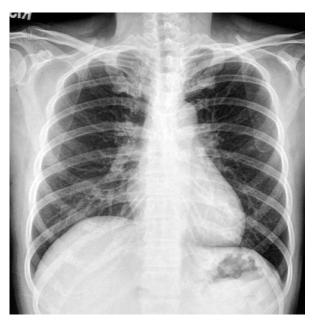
No definite airway or parenchymal lesion was noted in the chest X-ray.
